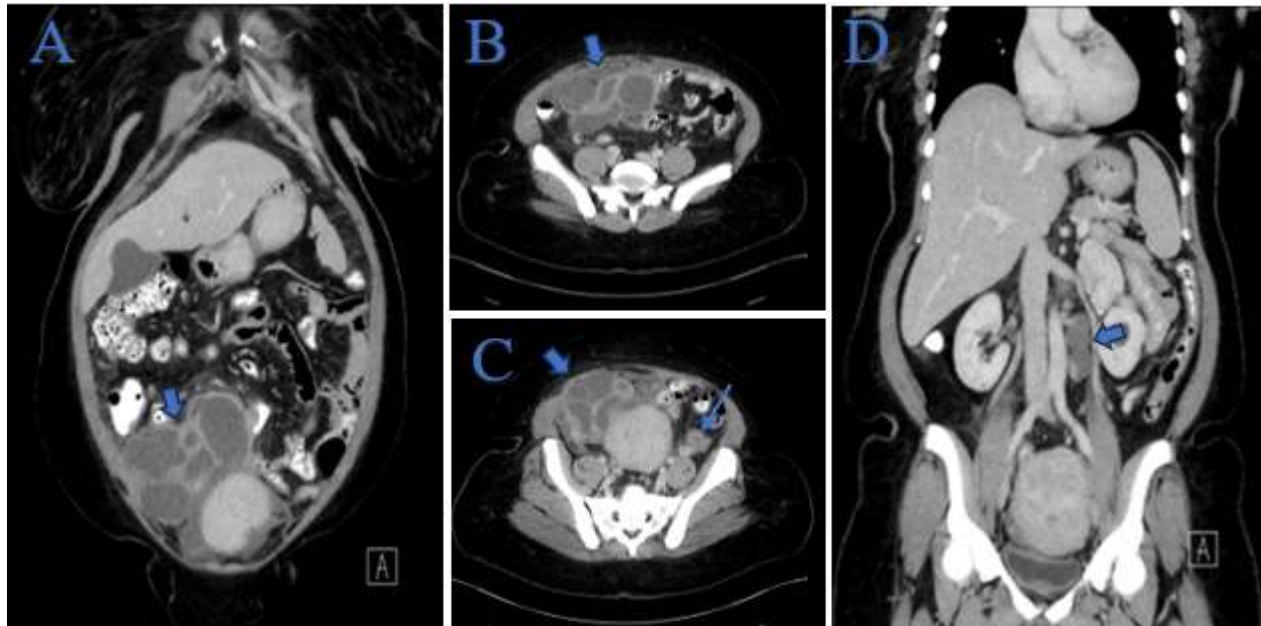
Computed Tomography (CT) with IV contrast in the portal venous phase images. (A) Coronal image, (B) and (C) Axial images showing multilocular right adnexa cystic mass with thick enhancing walls and significant surrounding fat stranding, soft tissue thickening, and omental nodularity (short solid arrows), (C) The left ovary showed rim enhancing cystic lesion measuring 2.2 cm (long solid arrow). (D) Coronal image showing enlarged left para-aortic lymph nodes with cystic area suggesting necrosis (short solid arrow).
